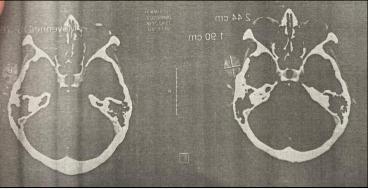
Axial section of cervico-facial MRI
